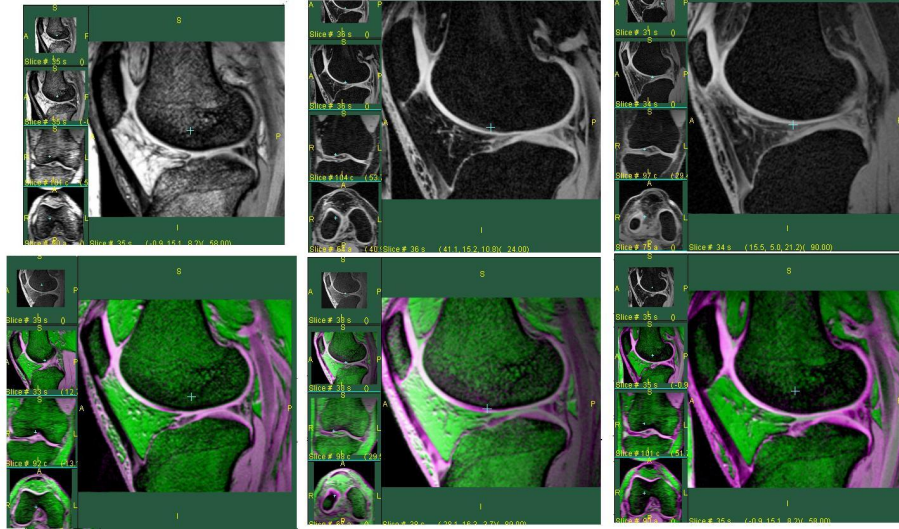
Middle Slice trough the five different analyzed scans. Top left, a T_2 weighted MRI of the knee. Top center, the first fat suppressed scan. Top right, the second fat suppressed scan. From Bottom left to bottom right, a slice trough the fused data sets
